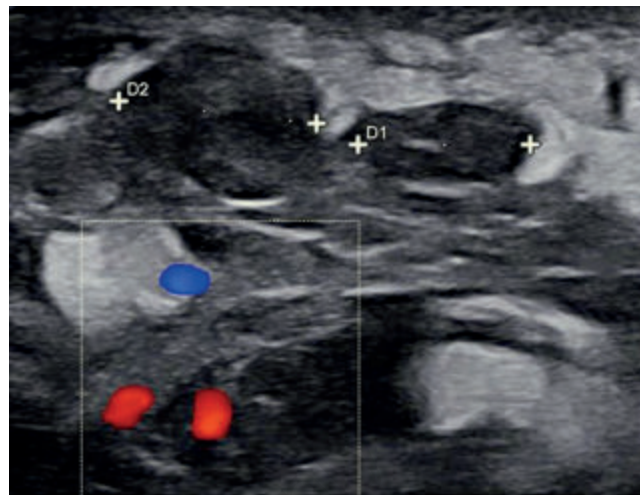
Image of the ultrasonographic exam of the left upper limb demonstrating the presence of nodular hypoechoic masses in the soft tissue. D1 and D2 are referred to as lesions' diameter.
